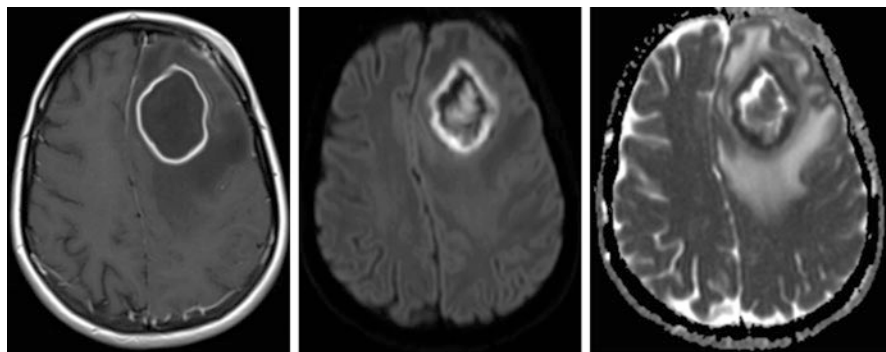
Left frontal abscess after complicated sinusitis with ring enhancement on T_1 -weighted DCE-MRI with Ga-DTPA and restricted diffusion (high DWI and low ADC) in the border and central in the lesion
